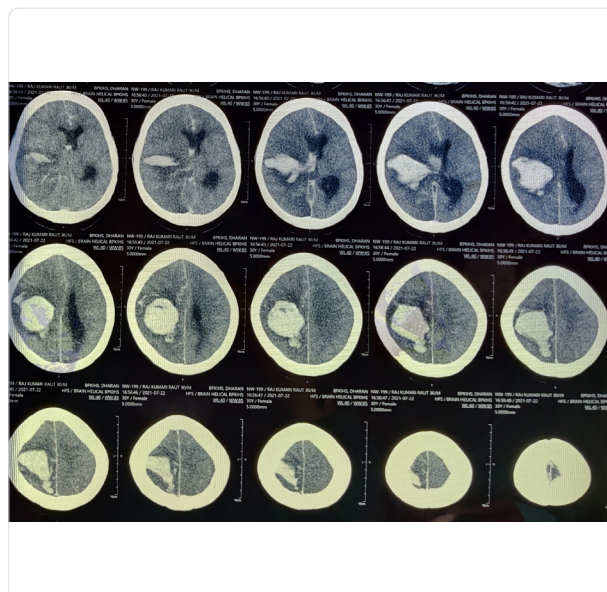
CT scan of head showing left fronto-temporo-parietal intraparenchymal hematoma with intraventricular extension with mass effect and subarachnoid haemorrhage.
